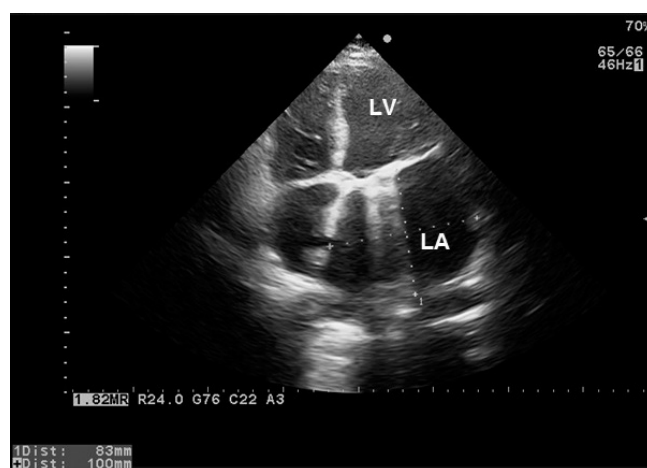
Transthoracic echocardiogram (apical 4-chamber view), showing the disproportionate size of the left atrium (LA) compared with the left ventricle (LV) and the other cardiac chambers.
